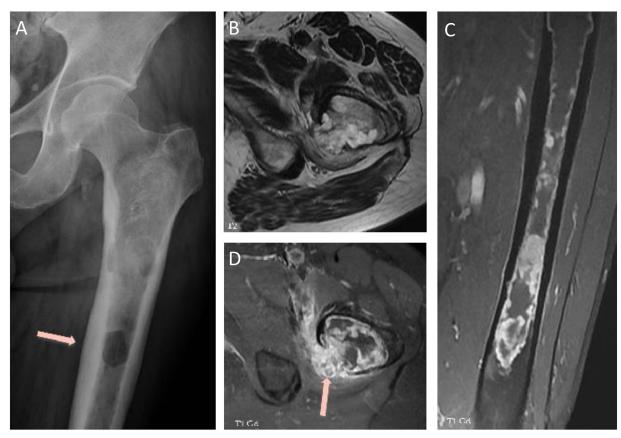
AP plain radiograph of the left femur (A) shows a well-defined lytic lesion (arrow) within an infiltrating intramedullary lesion in the left femoral diaphysis, with deep endosteal scalloping. MR demonstrates a high heterogeneous T2 signal (B) with cortical breakthrough and soft-tissue mass. FS T1WI with contrast shows intense peripheral enhancement (C) and cortical rupture (arrow in D). Anatomopathology confirmed a grade 3 chondrosarcoma. (Color version of figure is available online.)
